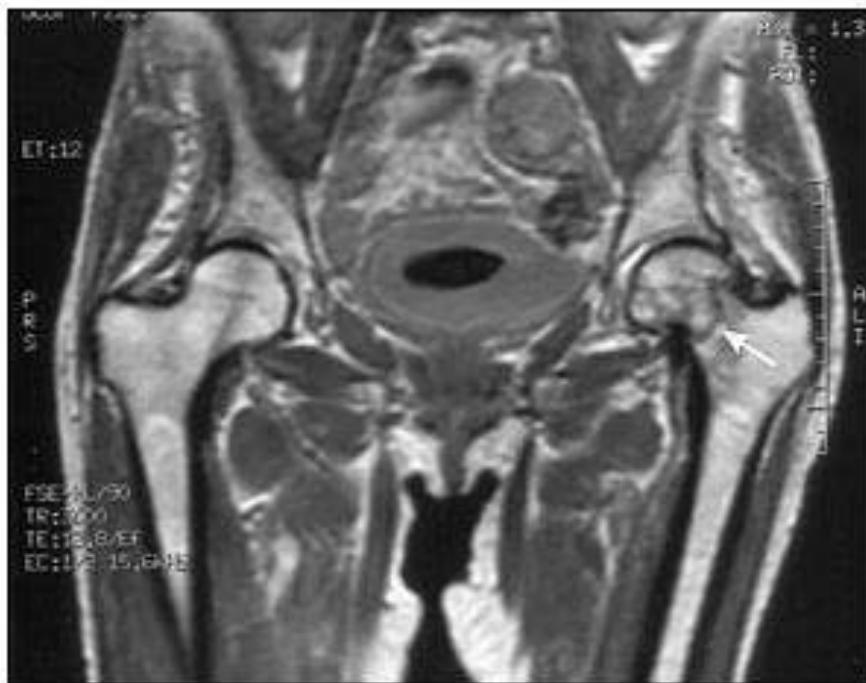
Coronal T₁-weighted magnetic resonance imaging study of the hip joints in the patient in Figure 1. This study confirmed the presence of a left nondisplaced femoral neck fracture (arrow).
